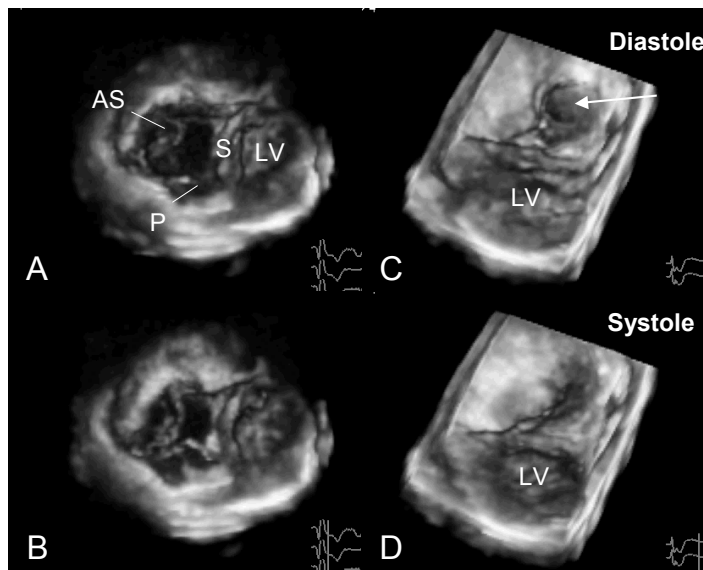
Real-time 3-dimensional echocardiographic display of Ebstein's anomaly of the tricuspid valve, seen from a ventricular view. A and B (diastole – systole) show the tricuspid valve 'en face' before valvuloplasty. C and D show the tricuspid valve after Chauvaud valvuloplasty. Note that the tricuspid valve has become a monocusp (arrow).
